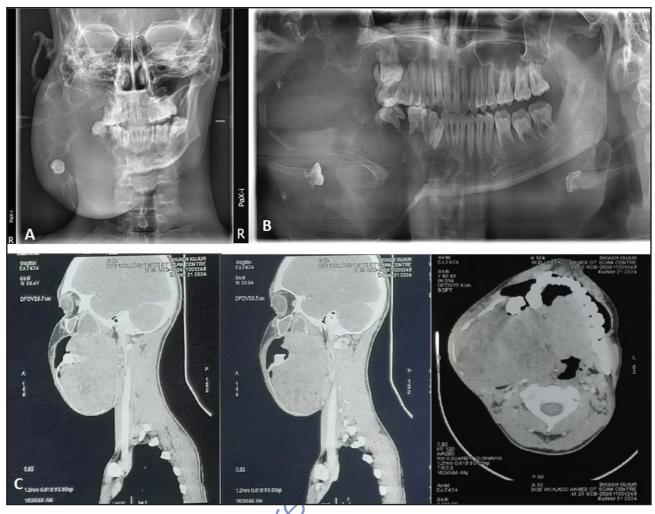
(A, B, and C) Radiographic evaluation of the expansile lesion.
